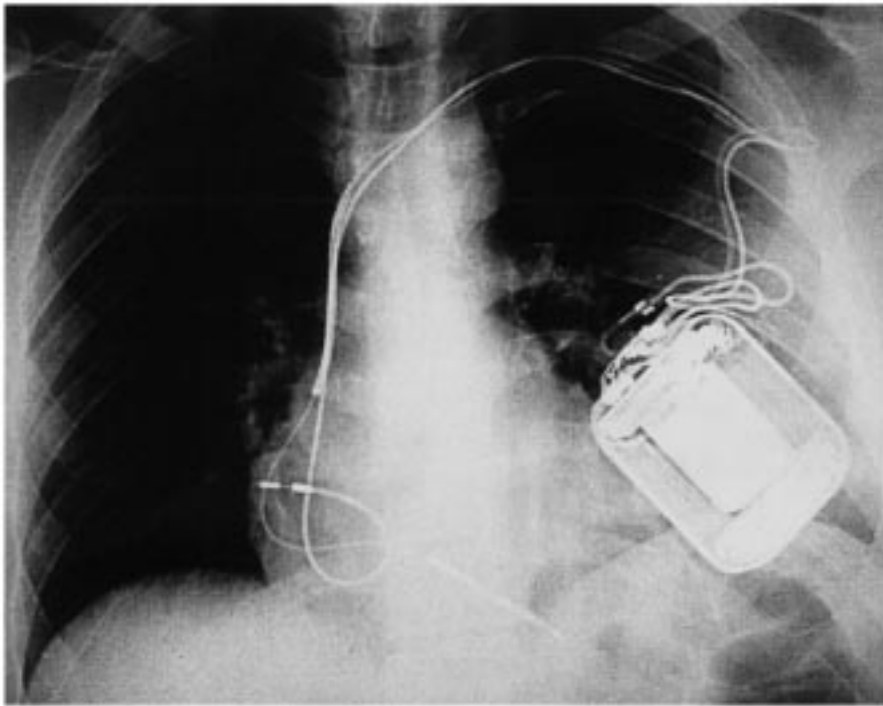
Anteroposterior chest radiograph after a submuscular dual-chamber defibrillator implant. Note the “omega” loop at the site of electrode attachment, and the placement of lead slack just lateral to the pulse generator.
